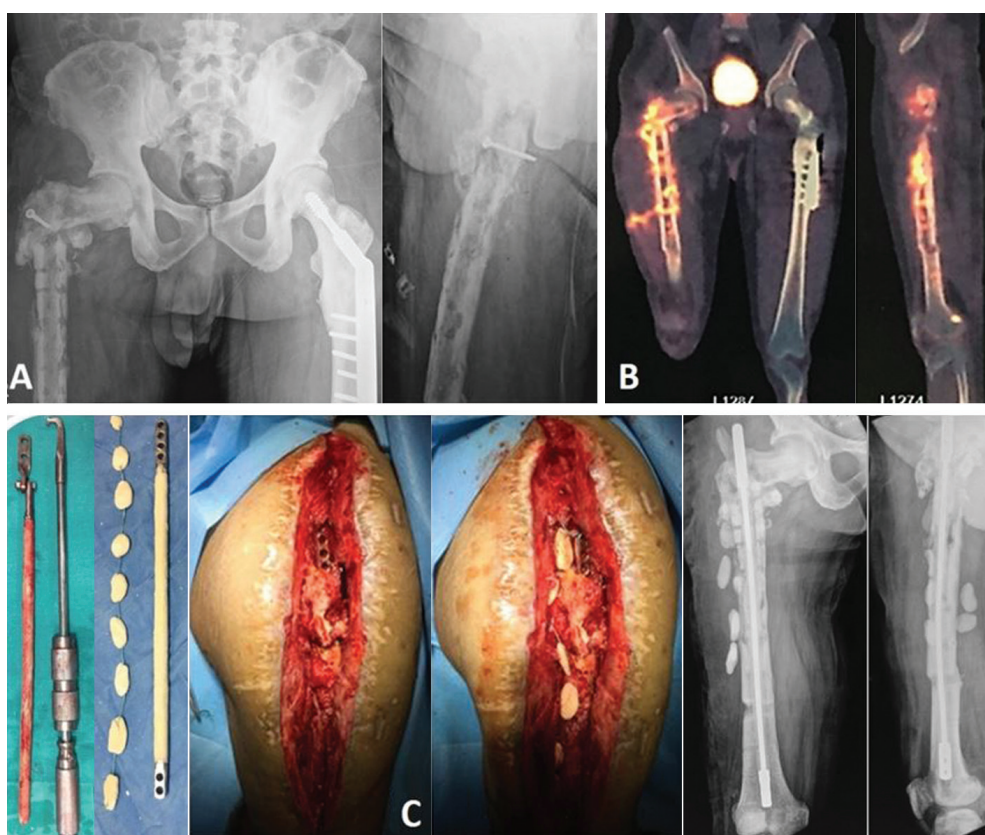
(A) Infected non-united subtrochanteric fracture in a 49-year male with multiple previous failed surgeries; (B) FDG-PET scan showing hot spots in the entire medullary canal and proximal femur; (C) custom made Ilizarov antibiotic nail, comprising of a threaded rod with posts at either end, coated uniformly with antibiotic impregnated cement (3 such nails were used), to control the medullary infection, until the discharge ceased
